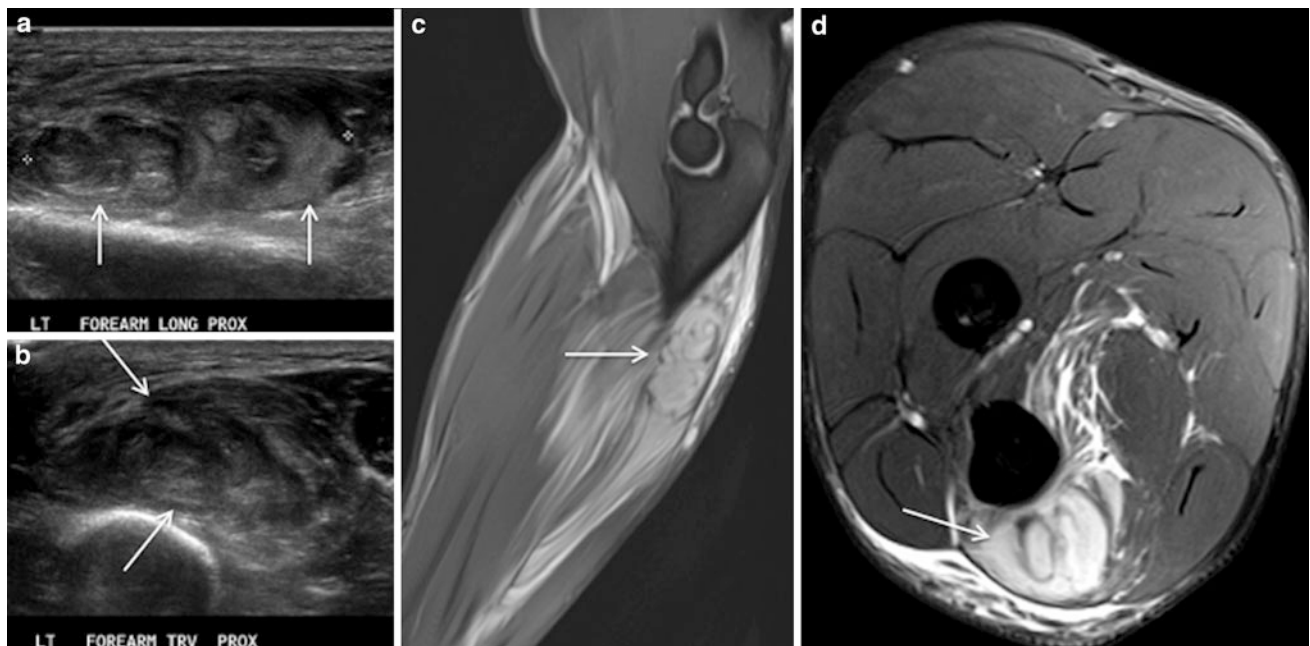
Longitudinal (a) and transverse (b) US images and sagittal (c) and axial (d) proton density weighted MR images with fat saturation in a professional rugby league player demonstrate an acute haematoma following a contusional injury involving flexor digitorum
